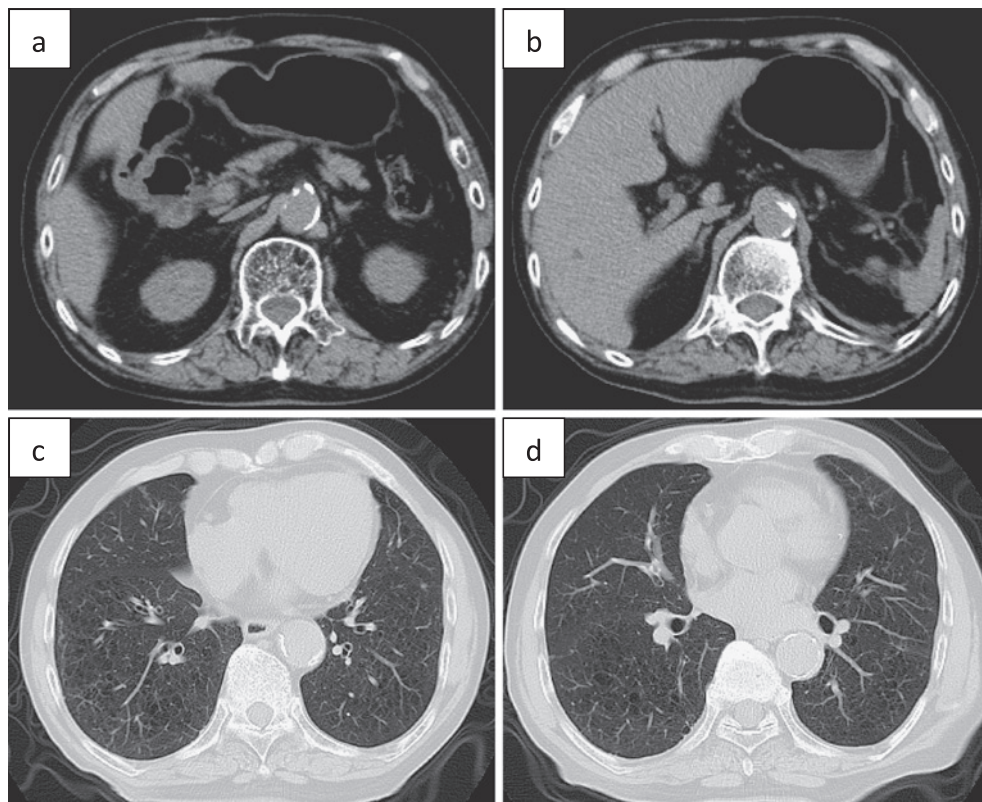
Follow-up abdominal CT showing that gastric wall thickness and the nodules in the liver had disappeared, (a) and (b). Follow-up chest CT showing that the nodules in the lung had disappeared, (c) and (d).
